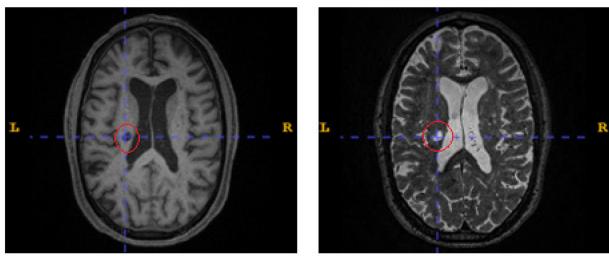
Lesion appears dark on T1-weighted (left) and bright on T2-weighted MRI images (right).
